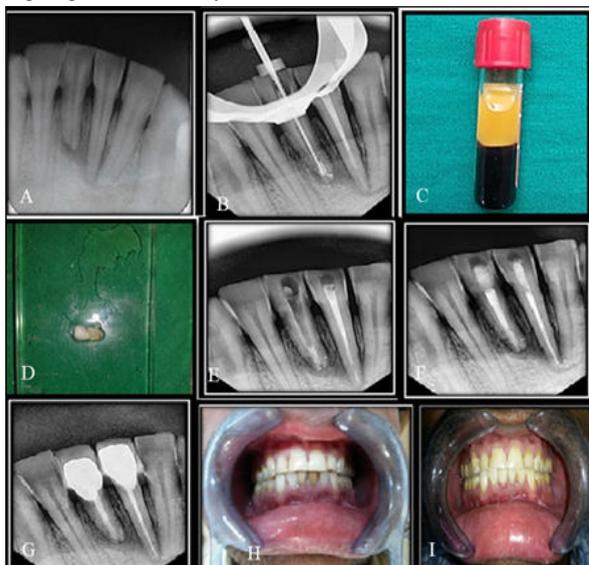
A) Pre-operative radiograph irt 11. B) Working length irt 11 C) PRF prepared D) PRF placed irt 11 E) MTA placed over PRF F) Post-operative view
